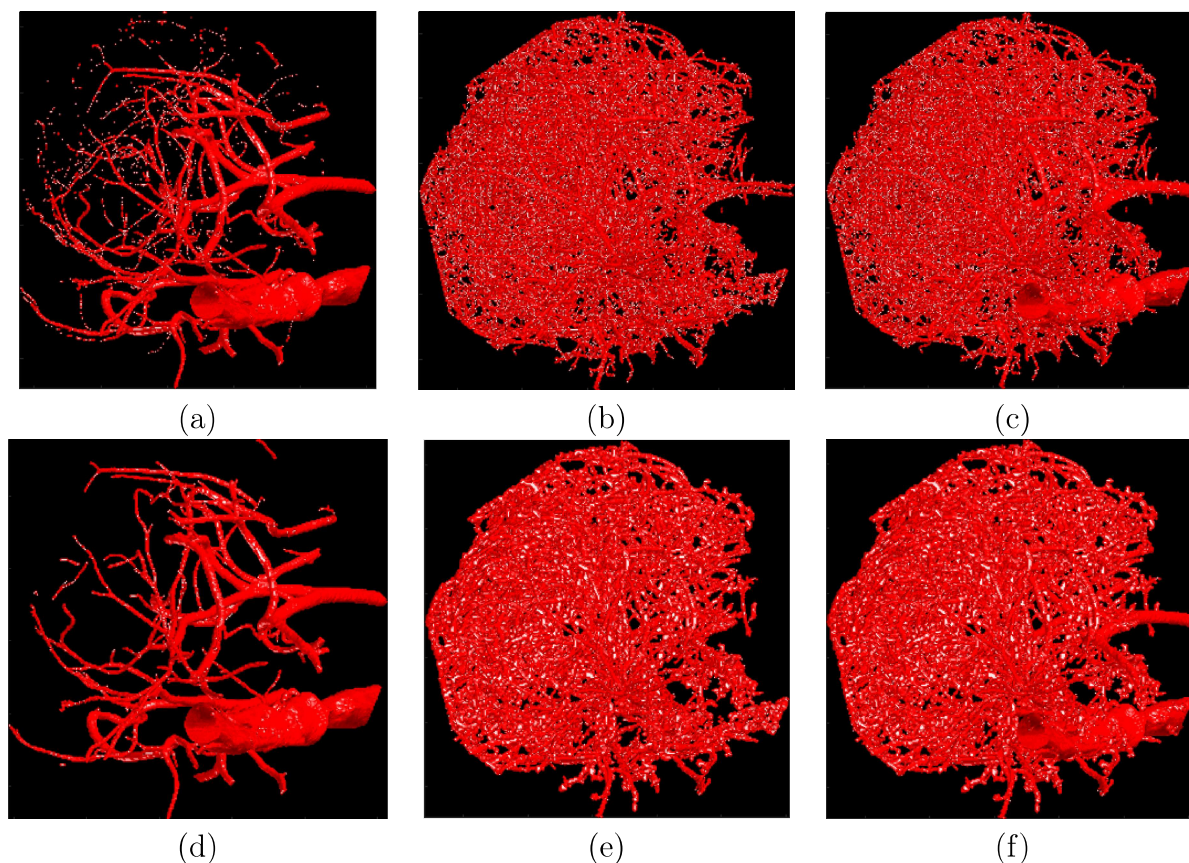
Visual comparison of two hybrid segmentation methods in-terms of segmenting different sizes of vessels in CT scan images. (a) medium to big vessels using multi-threshold Otsu method; (b) small to medium vessels using WHVEF in [37]; (c) whole vessel tree after adding the image using multi-threshold Otsu and image using WHVEF combined with ISODATA [37]; (d) medium to big vessels using multi-threshold Otsu method combined with hysteresis thresholding; (e) small to medium vessels using WBHVEF in [35]; (f) whole vessel tree after adding the image using multi-threshold Otsu combined with hysteresis thresholding and image using WBHVEF combined with hysteresis thresholding [35].
